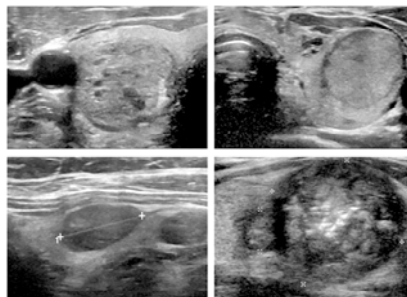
Ultrasound features that are typical for various risk groups of thyroid cancer
